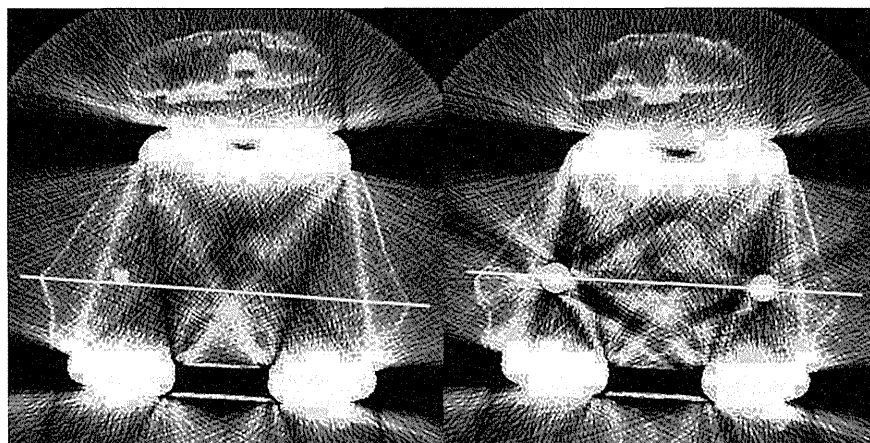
CT slices used to confirm the rotational alignment of the femoral component after operation are shown. The rotational alignment of the component is defined as the line connecting the center of the medial and lateral pegs.
